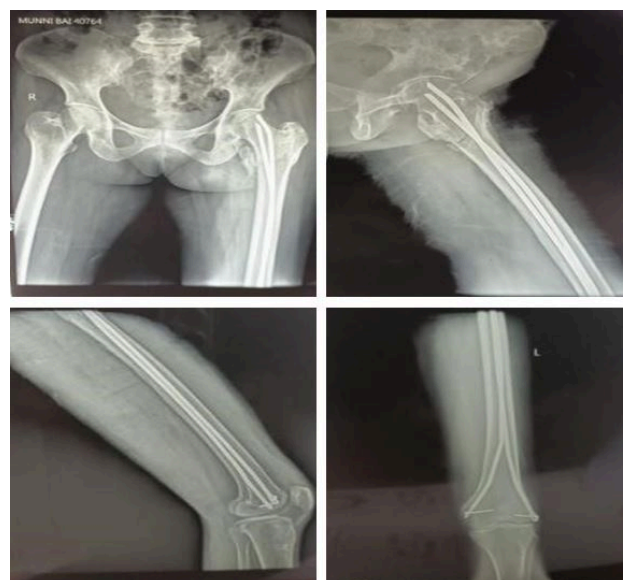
A, B, C and D, 4 week follow up X-ray showing healing of fracture without displacement.
